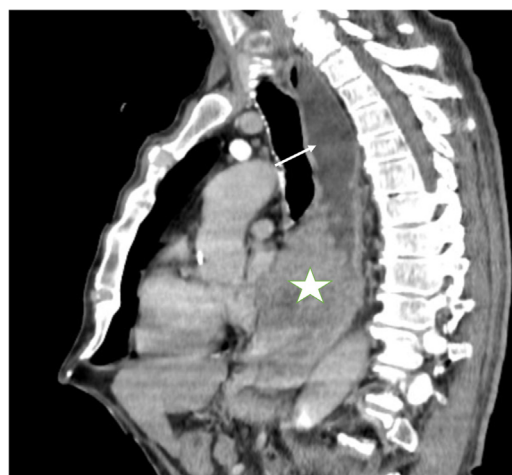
CT scan (sagittal plane) showing a lower esophagus mass (white star) with dilation of proximal esophagus above (white arrow).
